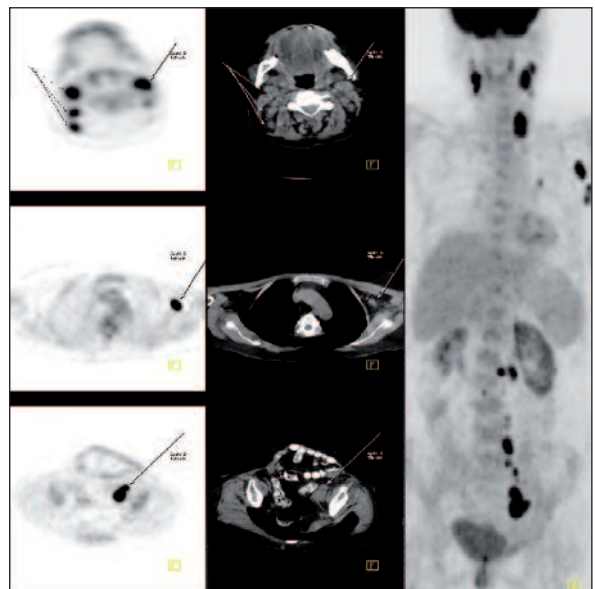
58-years-old woman with history of TAH-BSO secondary to ovarian carcinoma in 2003. During the follow-up, MRI showed multiple lymph nodes in pelvis and abdomen. Ca-125 level was in normal range. FDG-PET/CT detected these previously known abdominal and pelvic lymph nodes with additionally cervical and left axillary lymph nodes.
